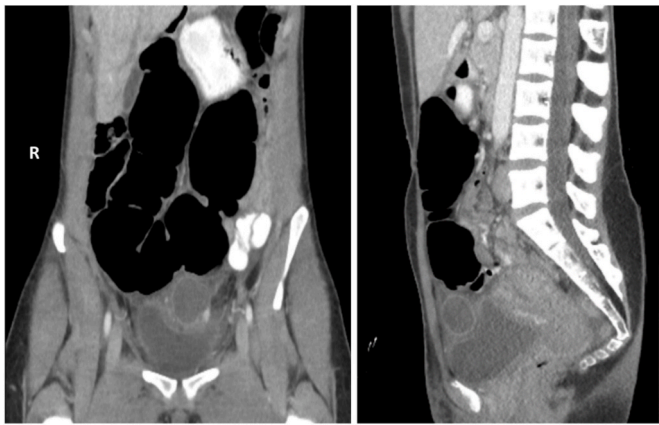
CT Scan showing a mixed cystic, solid mass superior to the bladder, with stranding around the bladder and anterior abdominal wall.
